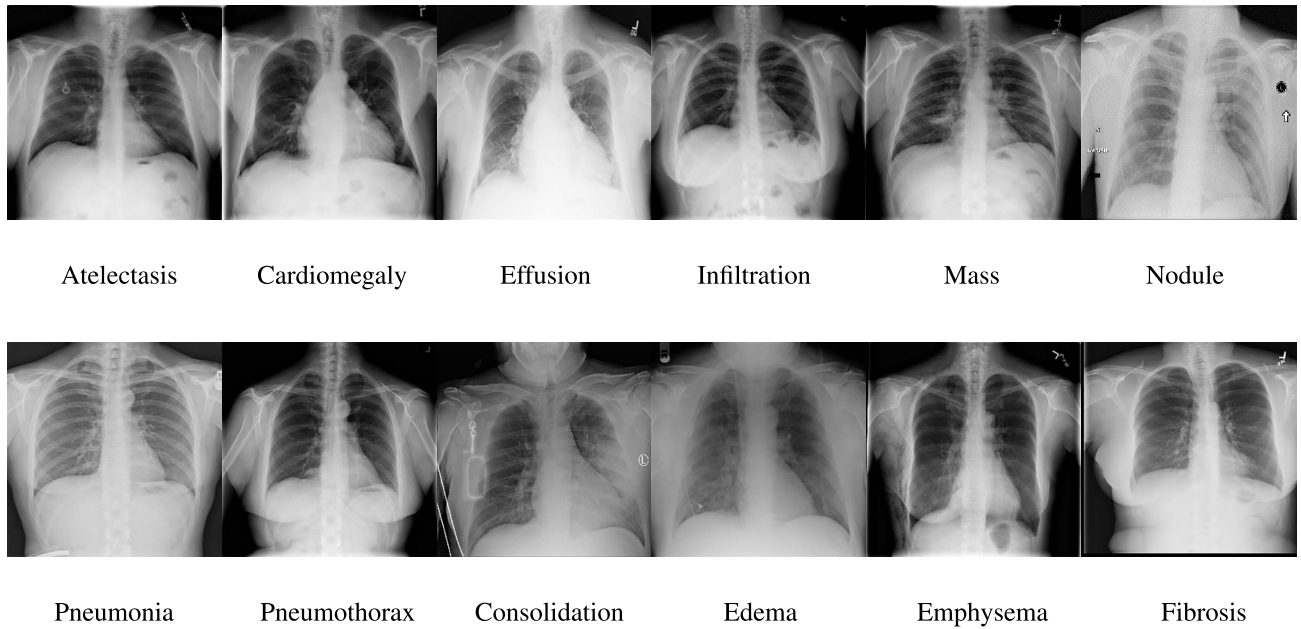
Example images and the corresponding labels in the Chest X-ray14 dataset.
